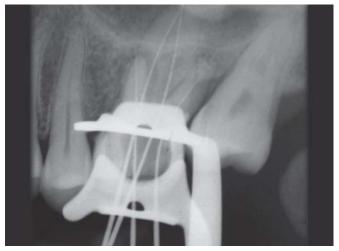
Periapical radiograph showing two canals in palatal root
